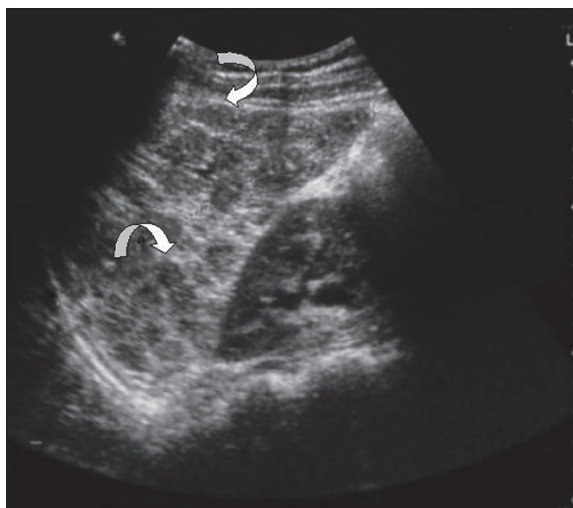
Case 2. Ultrasound of the liver: echogenic septa (curved arrows) outlining normal areas of liver parenchyma.
